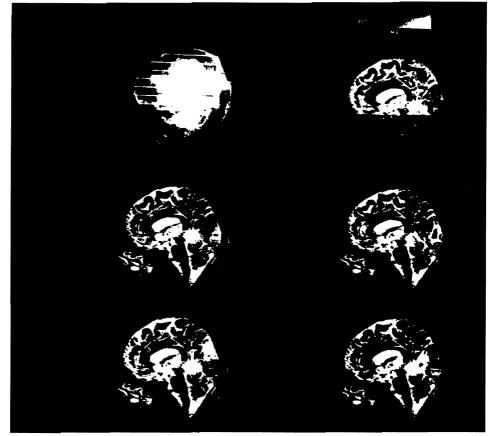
PET-MRI superimposed images from the same subject, showing cortical responses due to visual cortex stimulation. Top left: X-ray radiograph of the subject's head in the mid-sagittal plane with the centers of the seven horizontal PET planes delineated, plane 1 being the top-most plane and plane 7 the bottom-most plane. The remaining images are PET-MRI superimposed images localizing physiology on to anatomy. Shown to the left of each PET-MRI subtracted image is the stimulus used to activate the corresponding cortical structures. Shown at the top is the twodimensional linear scale used in the display of the images: the horizontal axis is used to represent the MRI data, with MRI image intensity increasing horizontally to the right; the vertical axis is used to represent the PET data, with PET image intensity increasing vertically downwards. Thus, points in the superimposed images that have maximal PET activity and maximal MRI signal are represented in the bottom-right of the scale. The red in the PET scale allows easier localization of the peak PET responses in the images. Top right: cortical response to macular stimulation without subtraction of the control scan. Center left: subtracted response to macular stimulation following subtraction of the control scan. Center right: subtracted response to perimacular stimulation. Bottom left: subtracted response to peripheral lower-field hemi-annulus stimulation. Bottom right: subtracted response to peripheral upper-field hemi-annulus stimulation.
